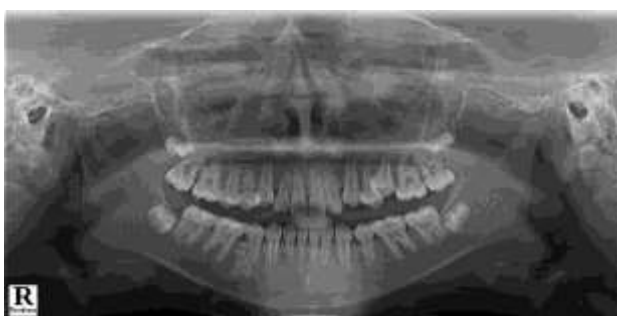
Panoramic radiograph of a patient with dens-in-dente with respect to 12 and missing 22
